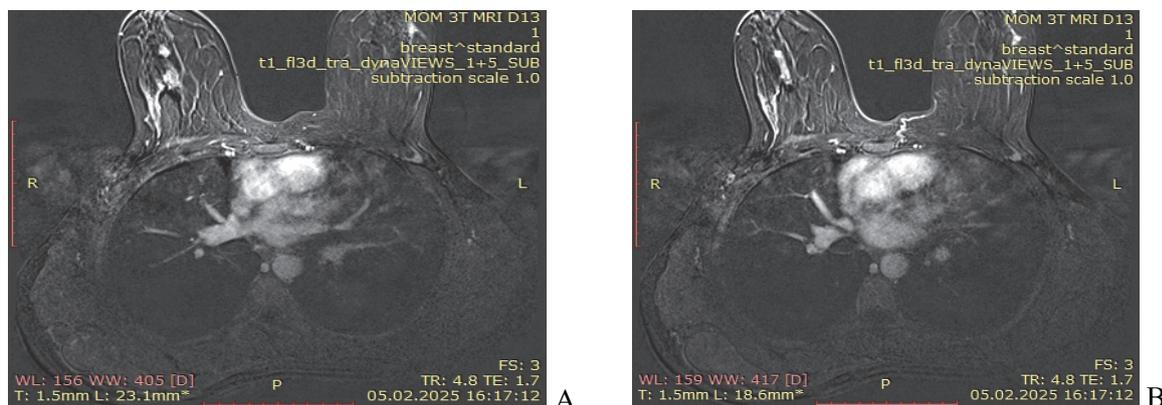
Subtraction MRI. A – Early Subtraction MRI (initial enhancement phase) shows the first linear non-mass enhancement, suspicious for an intraductal lesion. B – Delayed subtraction MRI (progressive enhancement phase) demonstrates more intense enhancement of the same lesion, reflecting vascularity and supporting suspicion for intraductal papilloma versus other ductal pathology. MRI categorized the lesion as BI-RADS 4.
